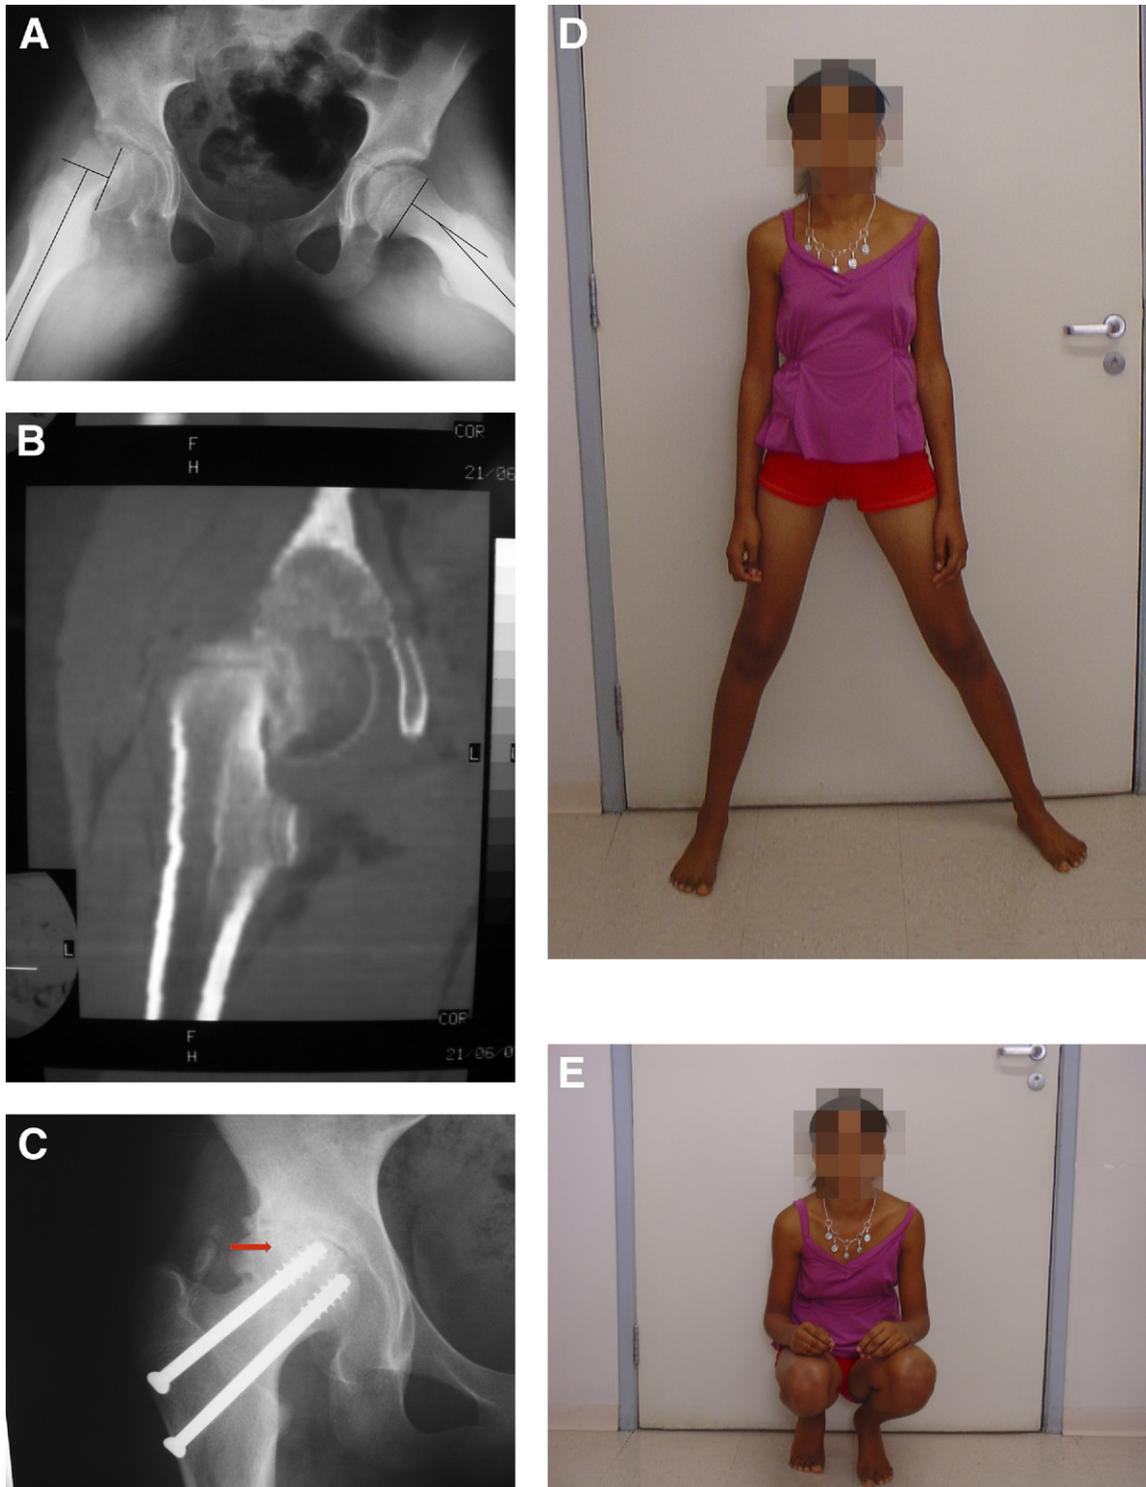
Imaging before, during, and after trapezoidal bony correction by arthroscopy in case 4. (A) Radiograph showing SCFE on right side in a 11.9-year-old girl. (B) Preoperative computed tomography scan of right hip. (C) Radiograph taken 1 year after surgery showing AVN (arrow) in right hip. (D and E) Photographs 1 year after treatment, showing (D) abduction of hip and (E) flexion of hip.
